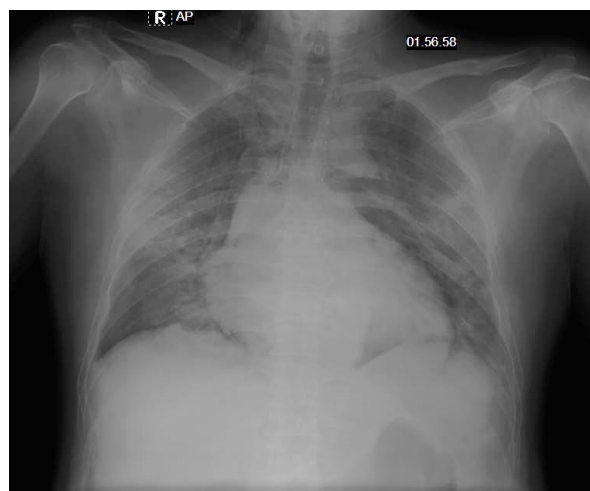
The patient's chest X-ray (AP view) on June 23, 2020, showed pneumonia, a suspected superior mediastinal mass, suspected pneumomediastinum, and subcutaneous emphysema in the right neck region.
